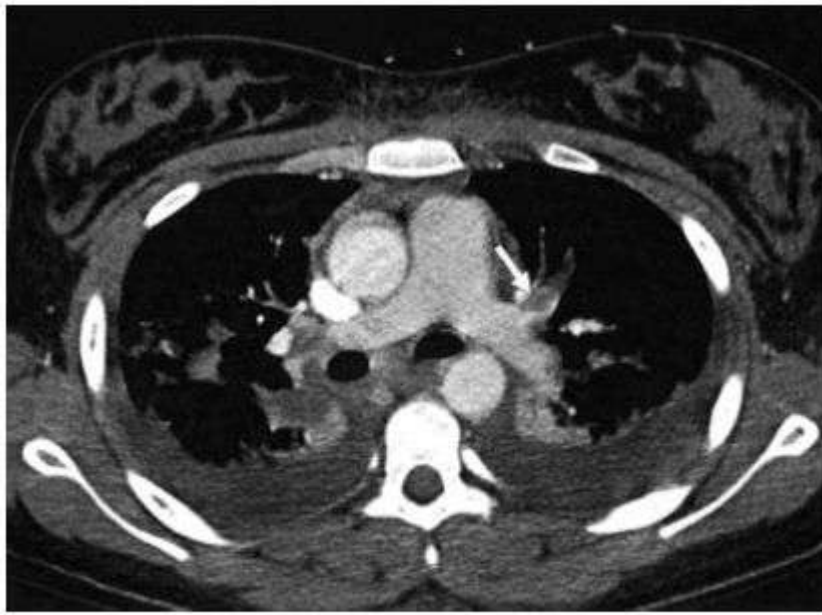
Computed tomography of the chest showing pulmonary arterial thrombosis (arrow).
